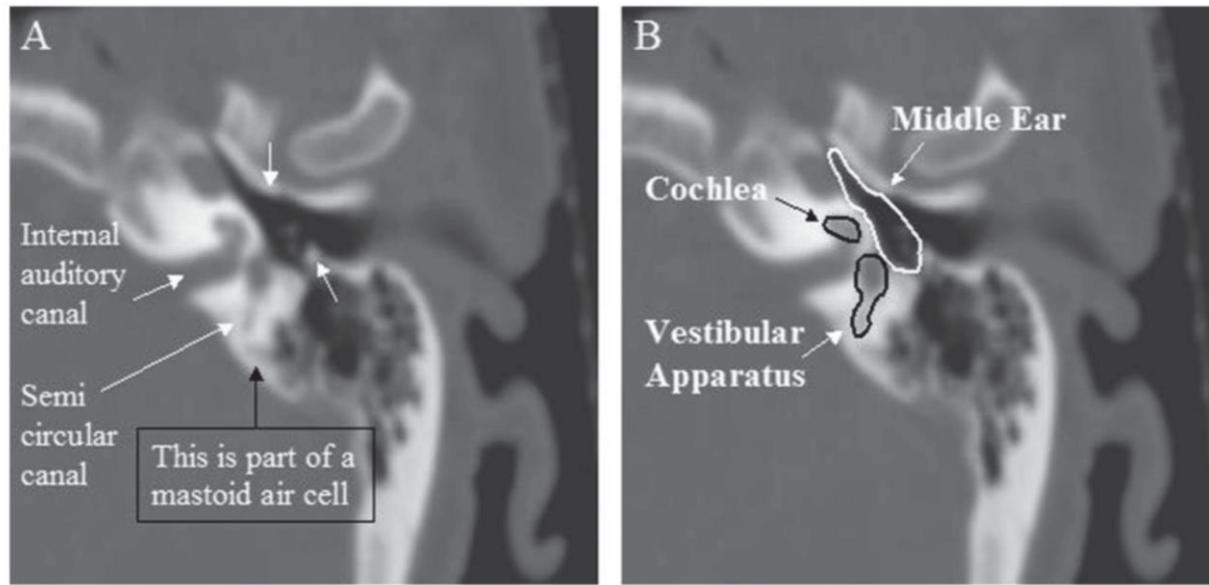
From Pacholke et al (2005): Major anatomic landmarks for identifying the cochlea on the axial images of a treatment planning computed tomography scan. The best way to locate the cochlea is to first identify the internal auditory canal. The image on the left (A) shows the anatomy of the temporal bone at the level of the inner ear without outlines of auditory structures. Important landmarks on this image are the internal auditory canal, the semicircular canals of the vestibular apparatus, and the bony prominences that mark the attachment of the tympanic membrane (un-marked arrows). The spiral canals of the cochlea appear as small curved or round lucencies within the temporal bone (B). Note that portions of a mastoid air cell may look similar to a semicircular canal.
